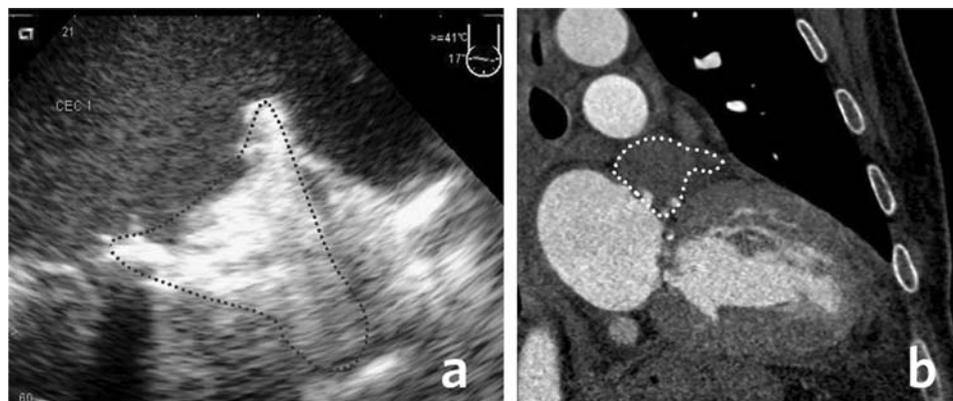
Transesophageal echocardiogram (a) and cardiac computed tomography (b) demonstrating complete occlusion of the left atrial appendage.
